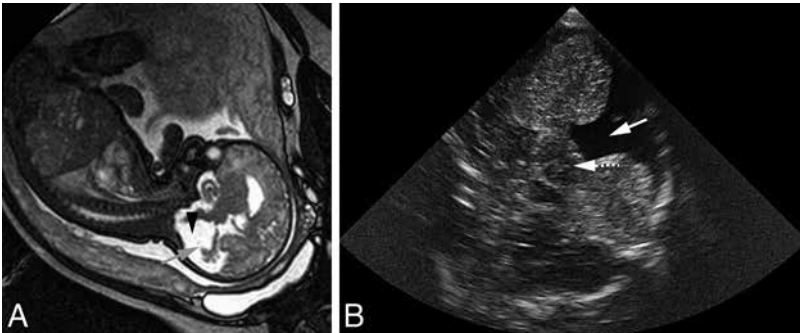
(A) Fetal MRI (gestational age 35 weeks) in neonate with PF malformation. Sagittal T2-weighted image shows a Dandy Walker malformation with an enlarged PF, a dilated fourth ventricle (arrowhead) and a hypoplastic, upward rotated vermis (arrow). (B) Postnatal axial CUS using the MF showing an enlarged PF and dilated, trapezoid shaped fourth ventricle (arrow) communicating with a retrocerebellar cyst. The vermis could not be detected. Dotted arrow indicates the pons, located anterior to the fourth ventricle.
